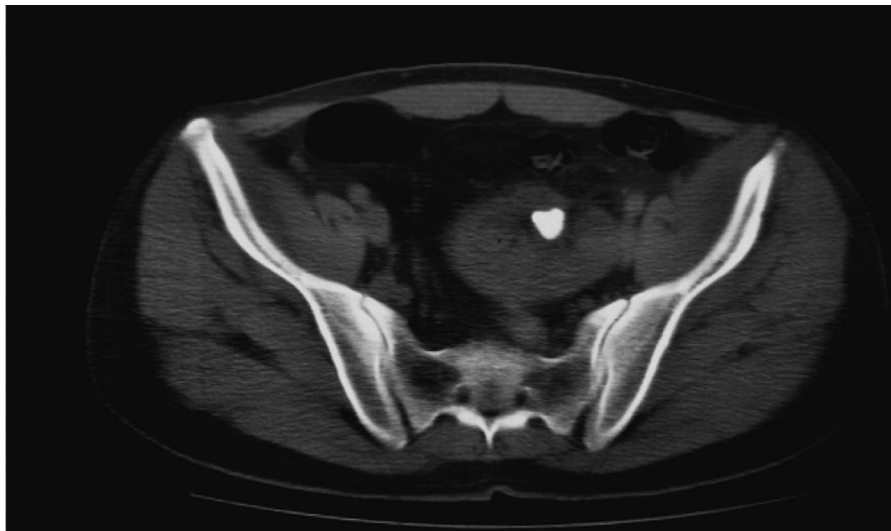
CT image of calculi.
